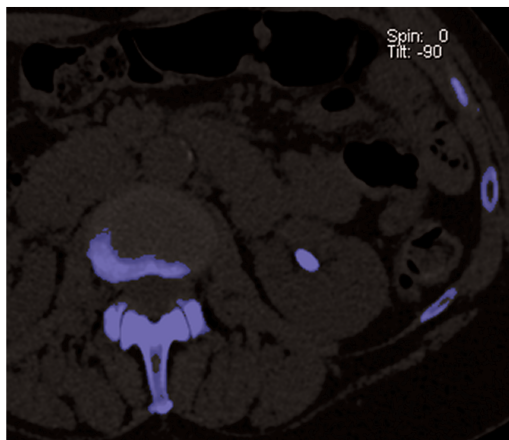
Slow kV switching for the characterization of kidney stones. Two consecutive spiral scans at 80 and 140 kV were performed with a 128-slice single-source CT scanner at 0.6-mm collimated slice width. Both low- and high-kV scans were nonrigidly registered. Calcium is highlighted in blue; the observed kidney stone is therefore considered to be calcified. (Courtesy of CIC, Mayo Clinic Rochester, MN, USA.)
